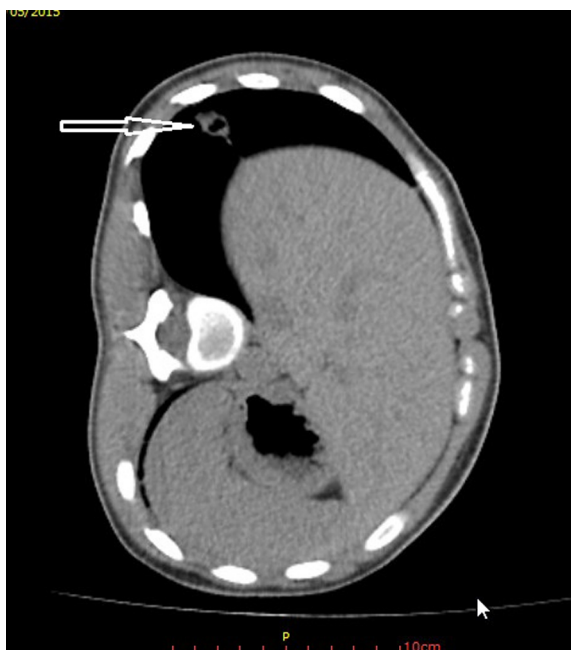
Another axial section of CT-thorax showing bronchiectasis.
